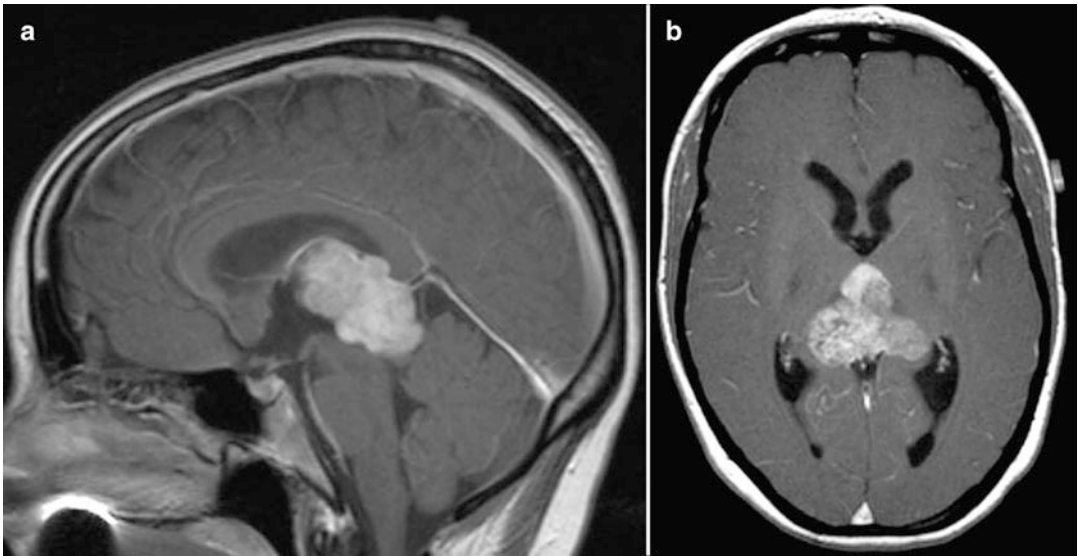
MRI features, T1-weighted image with gadolinium contrast enhancement. (a) Sagittal section, (b) Transverse section. Heterogeneously enhancing, lobulated mass is present in the pineal region
